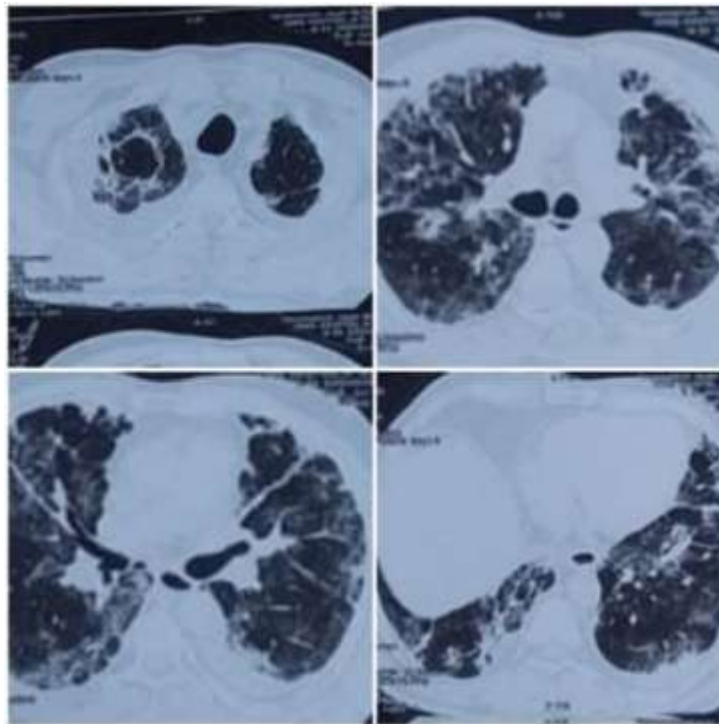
The first CT scan 6 days after symptom onset showed Bilateral ground glass opacities predominantly involving lower lobes
